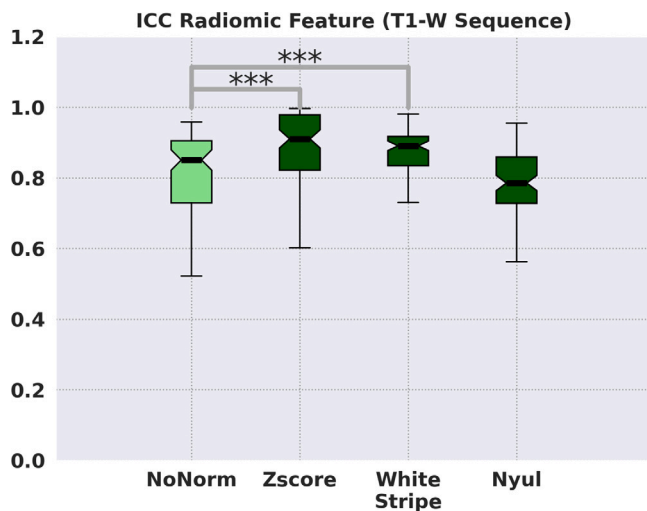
The distribution of ICC scores obtained from the radiomic features extracted from the non-normalized (NoNorm) T1-w MRI and the images normalized by the Z-score, WhiteStripe and Nyul methods. * (significant statistical difference).
